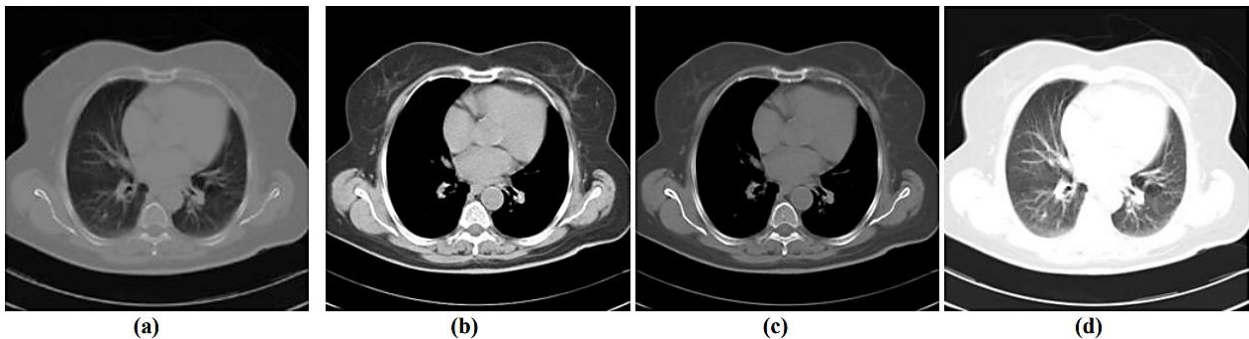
Chest CT image shown with multiple window settings: (a) original image and optimized brightness/contrast for (b) soft tissue, (c) bone, and (d) lung parenchyma. Adapted from (Jin et al., 2001a)
